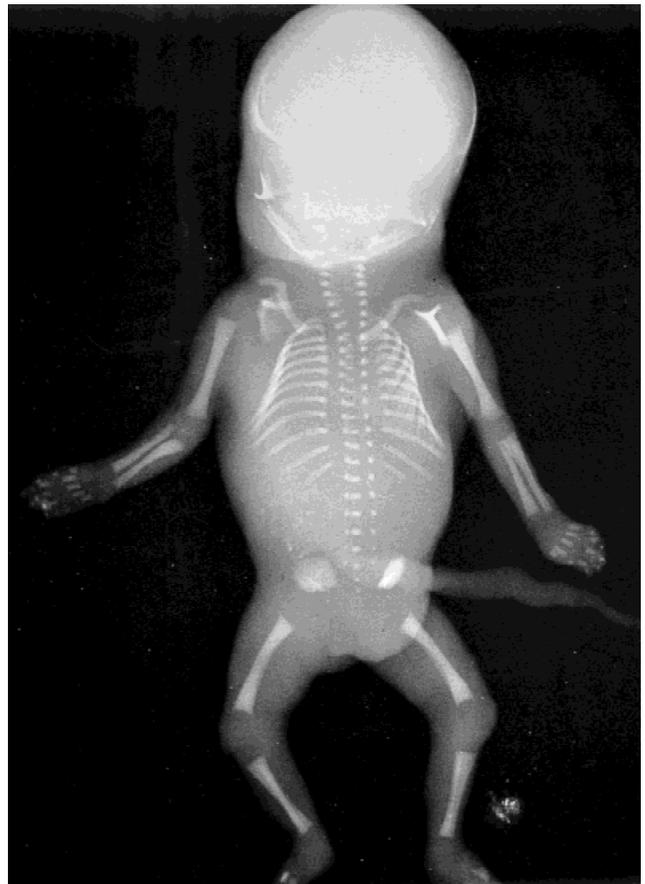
Radiograph of the fetus.
